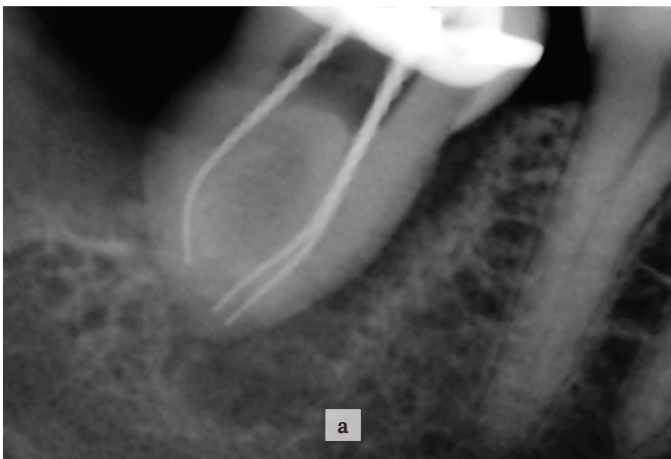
a, b. X-ray control of root canals instrumentation (in parallel and angulated projections).
